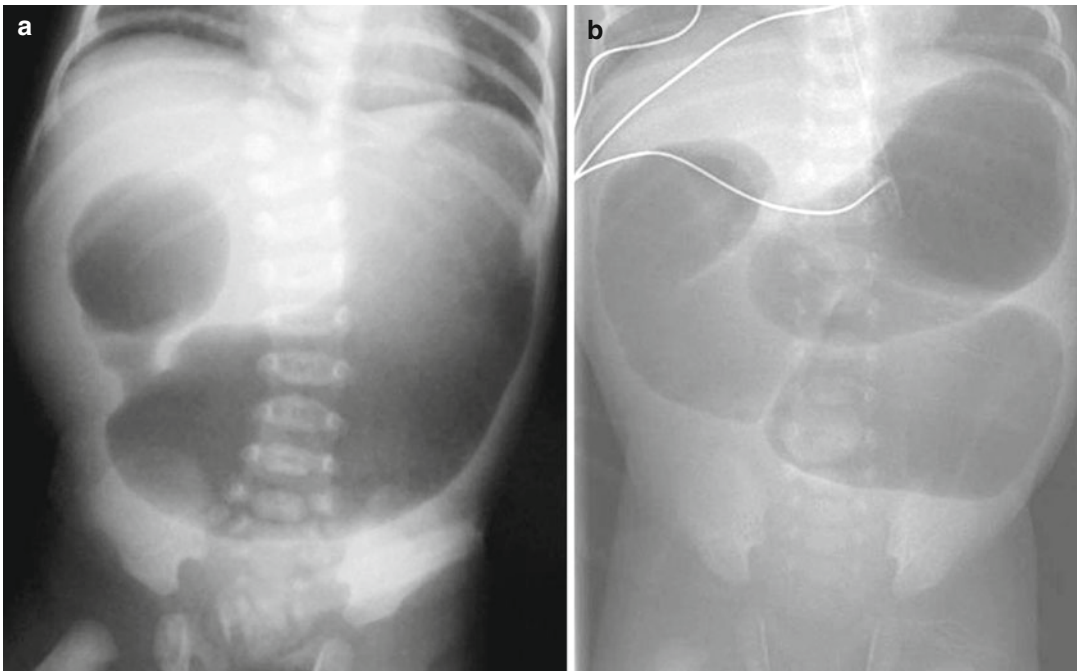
Plain abdominal radiographs: duodenal atresia with the double-bubble sign, due to distension of the stomach and proximal duodenum (a) and jejunal atresia
